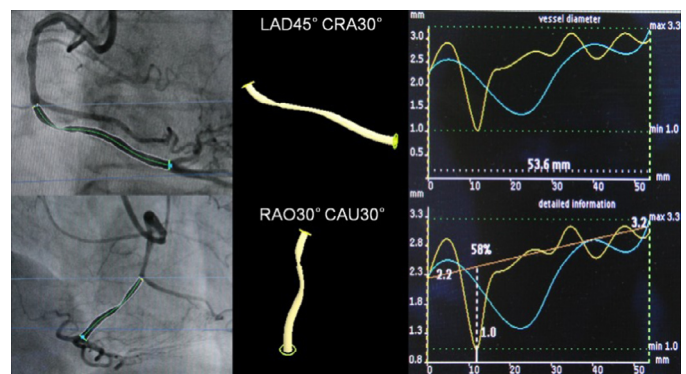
Three-dimensional quantitative coronary angiography: Segment of interest is reconstructed from X-ray coronary angiography to obtain lesion measurements (e.g. vessel diameter along segment). Reprinted from Lee et al. (2012) with permission from authors.
